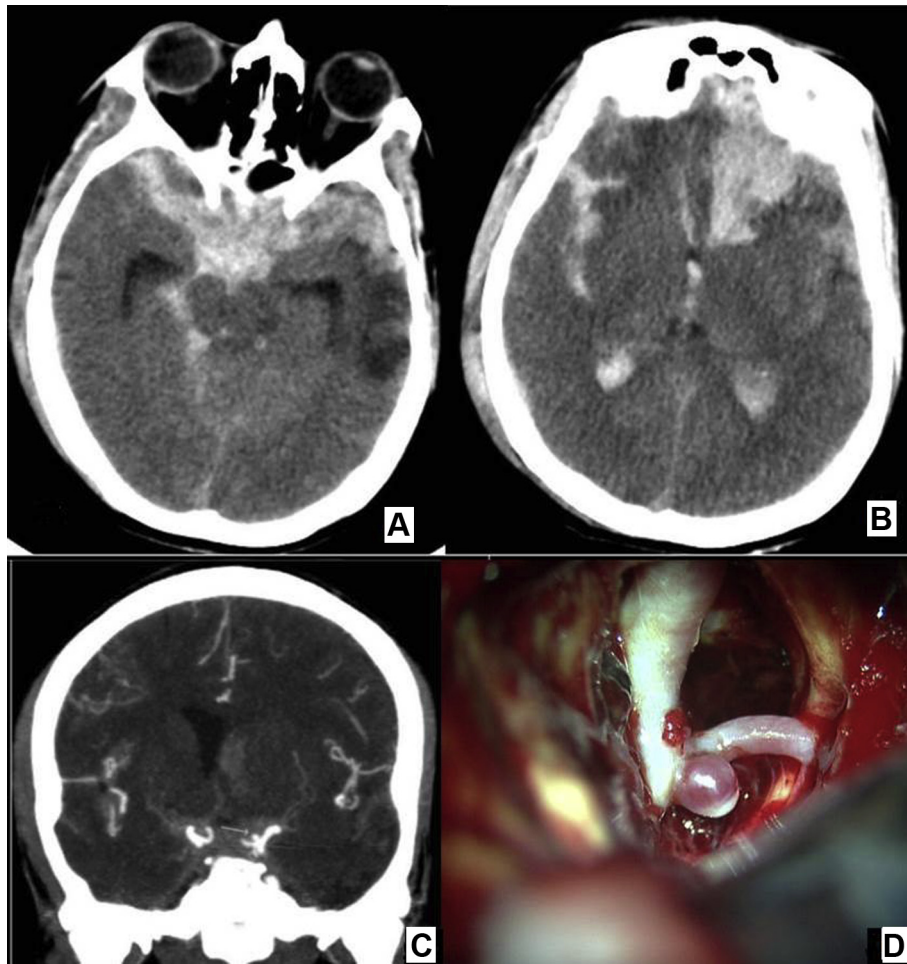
A and B: Plain CT scan axial section showing SAH in bilateral sylvian fissure and basal cistern, IVH, and left frontal ICH. C: CT angiogram, coronal section aneurysm at left ICA bifurcation. D: Operative photograph showing unruptured aneurysm at left ICA bifurcation.
